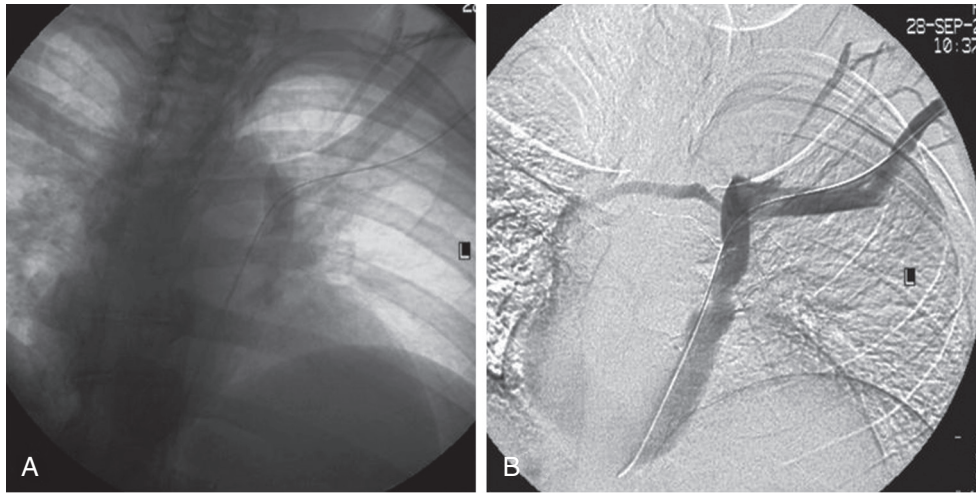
FIGURE e15-1 A, Portable chest radiograph demonstrating the location of a guidewire (used for placement of a peripherally inserted central catheter) in a left-sided SVC. B, Venogram confirming the variant left SVC and absent left innominate vein.
